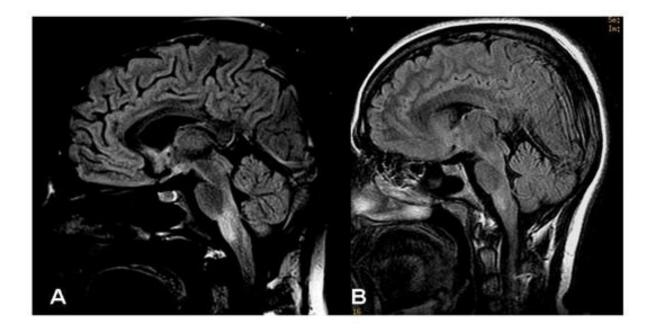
Net radiological response comparing the MRI of one month after the treatment (A) with that at 1 year of follow-up (B).
